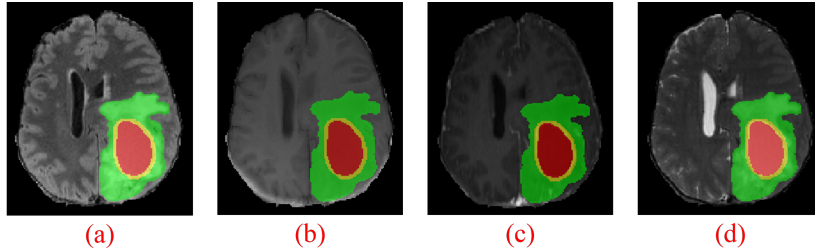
The four MRI modalities overlaid with their respective ground-truth (a) shows the Flair image, (b) shows the T1 image, (c) shows the T1CE image, and (d) shows the T2 image.
